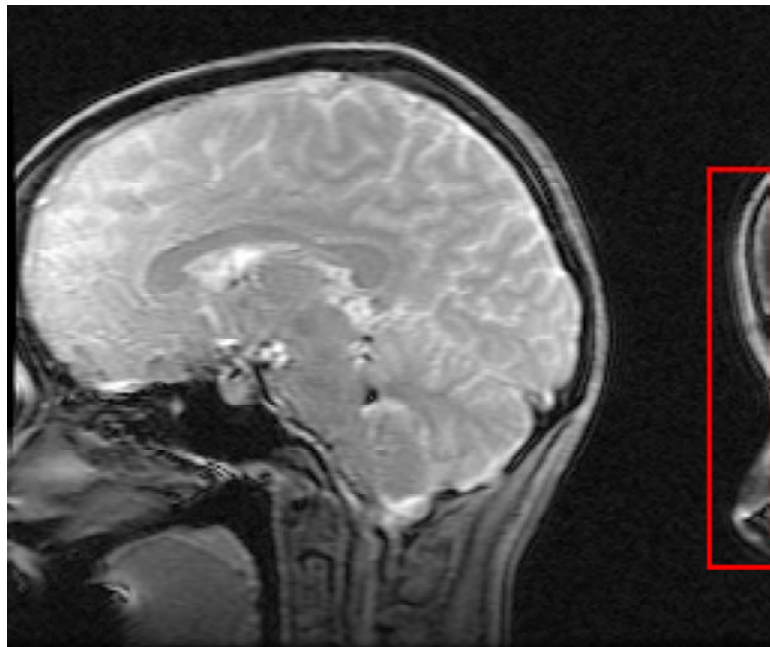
Aliasing concept in an MR image. The forehead and nose appear at the back of the head due to reduced FOV.
